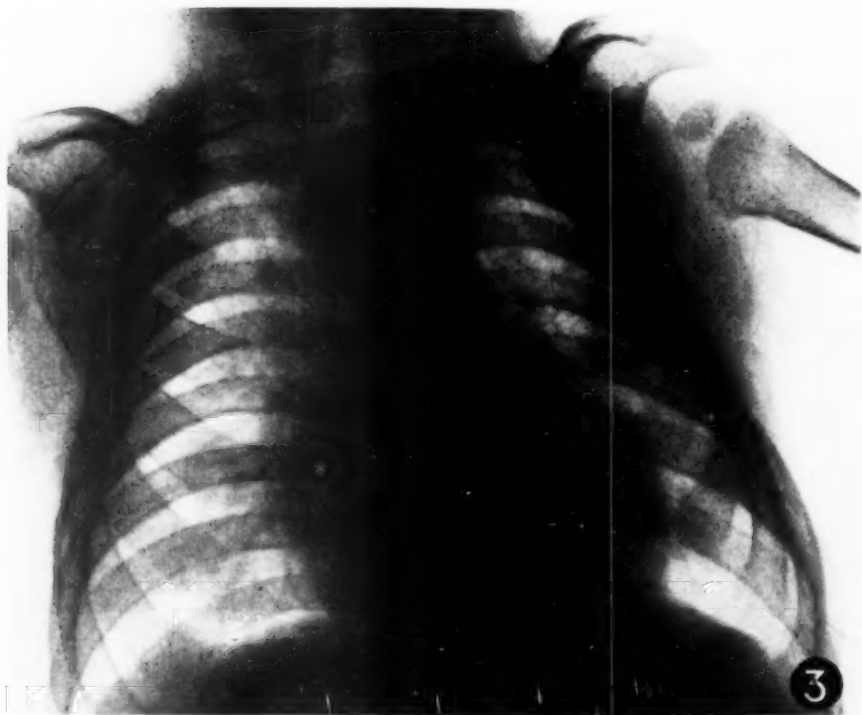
Radiograph of chest. Broad, ribbon-like, anterior ends of ribs.
